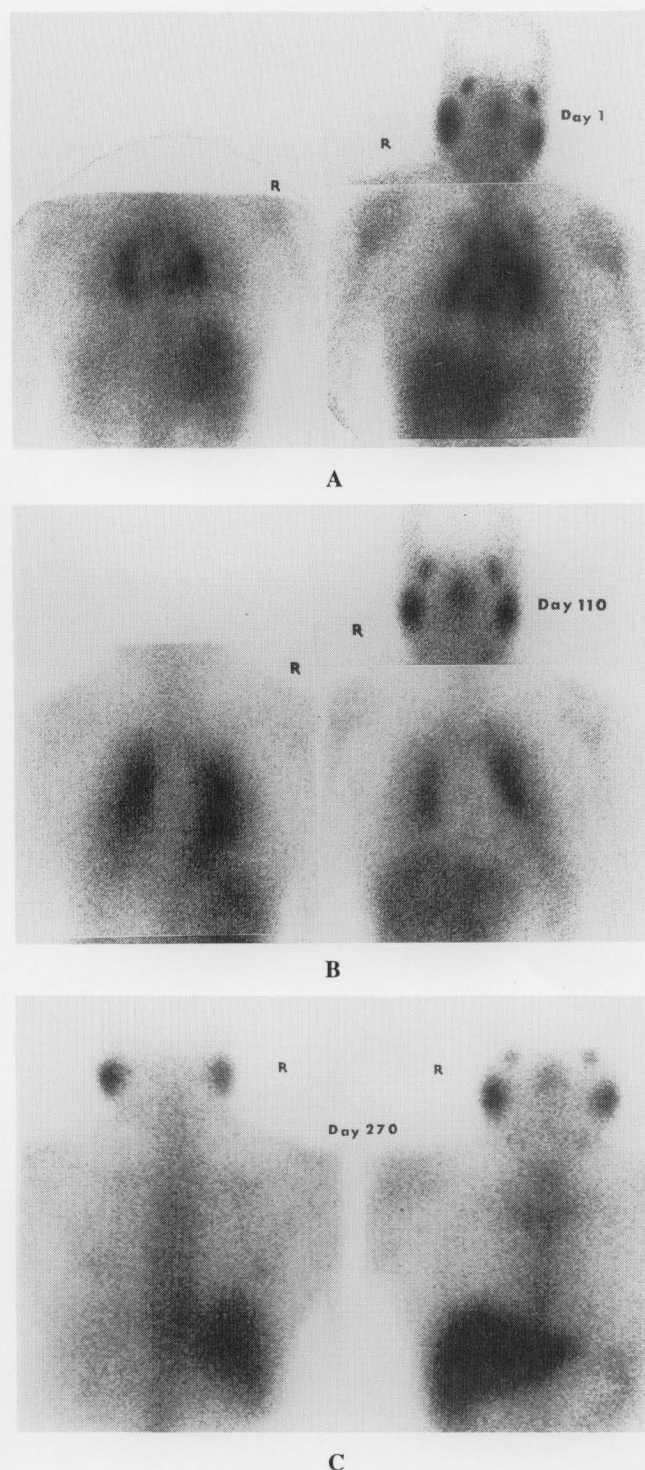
A, B & C: A baseline Ga-67 scintigraph with Stage I has progressed to Stage II (day 110) and undergone complete remission on day 270 (I to II to 0).
